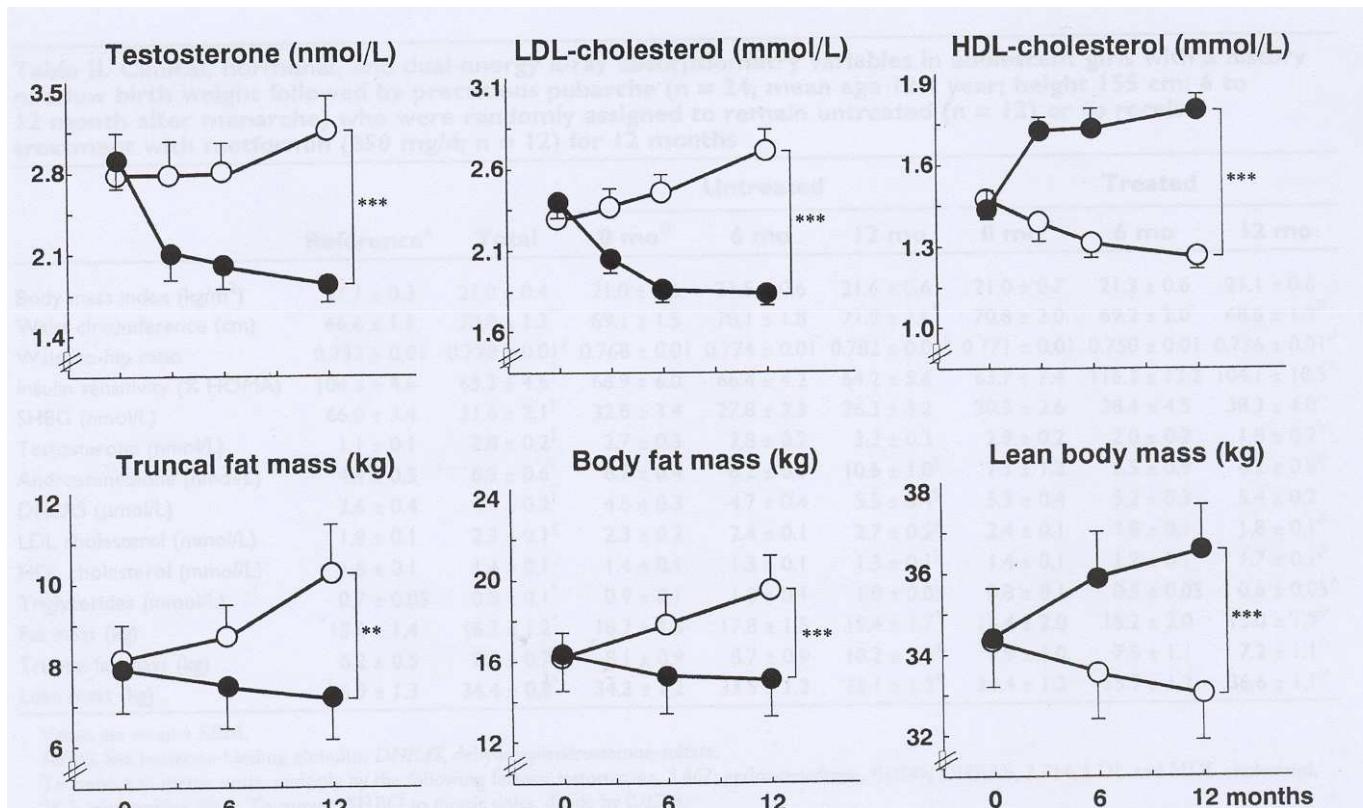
Serum testosterone and LDL and HDL cholesterol, together with body composition indexes (by dual-energy x-ray absorptiometry) in 24 postmenarcheal girls (mean age, 12.4 years) who had a small size at birth followed by precocious pubarche in childhood. Girls were randomly assigned to remain untreated ($n = 12$; open dots) or to receive metformin (850 mg/d; $n = 12$; closed dots) for 12 months. Values are shown as mean \pm SEM.  $P < .005$; * $P < .0001$; broken lines indicate mean reference values (Table II).
